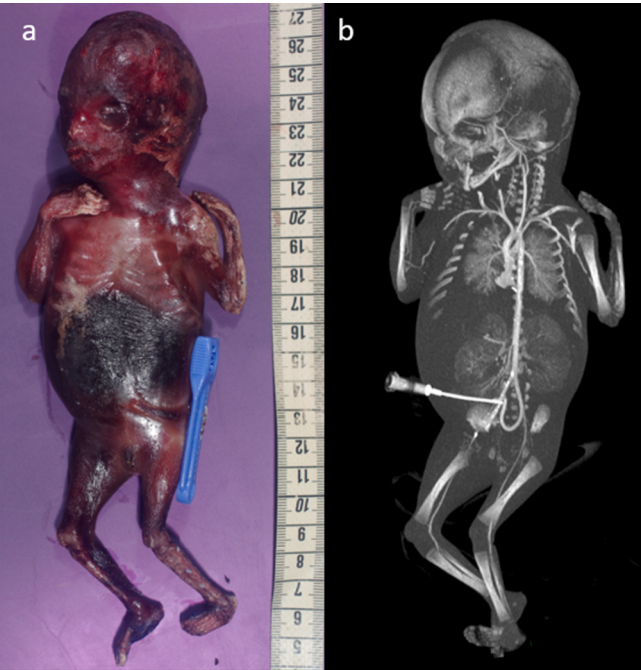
Fetus deceased at 146 days of gestational age. The postmortem interval between expulsion and examination is 23 months. The stage of postmortem alteration is advanced (a), however CT angiography image in anterior view using Maximal Intensity Projection (MIP) after arterial opacification consecutive to the injection of 1 mL already demonstrates a good opacification of great vessels (b).
